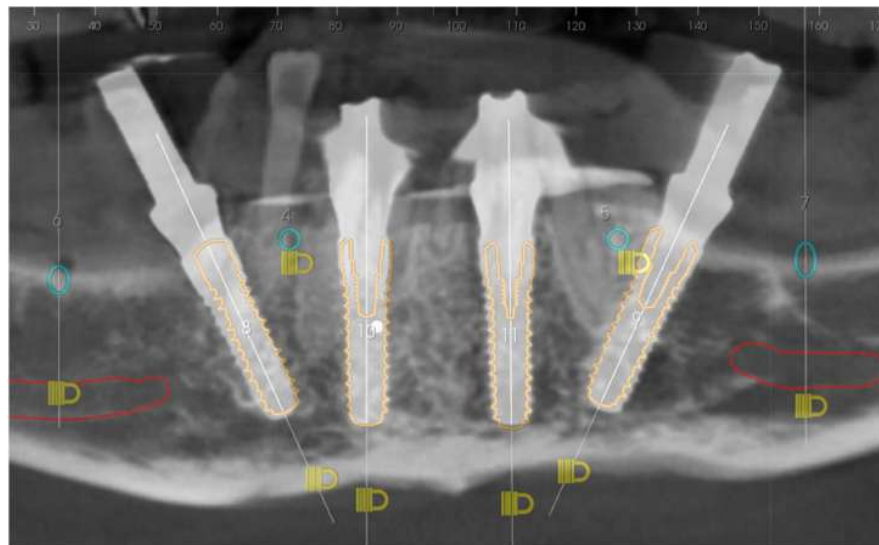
Comparison between digital plan and post-op CBCT.
